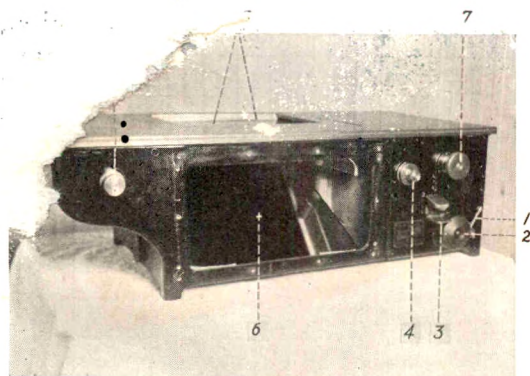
Outer appearance of camera, cloth hood for roentgenoscopic observation of each exposure removed. 1. Motor switch. 2. Contact for roentgenoscopy. 3. Contact for exposure covered by protecting roof. 4. Shaft of gear, selecting desired length of exposed film sections (see Fig. 4—No. 5). 5. Diaphragm. 6. Mirror for visual observation of roentgenoscopic image (see Fig. 1—Nos. 10 and 11). 7. Rods mounting film spools.
